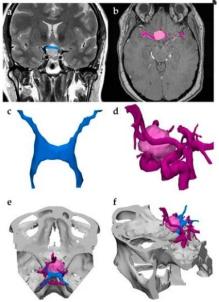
Multimodal Imaging for Three-Dimensional (3D) Printing: This approach was applied to visualize a brain tumor and differentiate it from the adjacent optic nerve and surrounding vasculature. (a) The optic nerve was imaged using magnetic resonance imaging (MRI) and represented in blue after segmentation. (b) Computed tomography (CT) was instrumental in delineating the neoplasm's boundaries, highlighted in pink, and identifying nearby vessels, highlighted in purple. (c, d) Subsequently, the segmented anatomical structures were transformed into stereolithography (STL) files, and (e, f) these files were integrated into a unified model for 3D printing.
